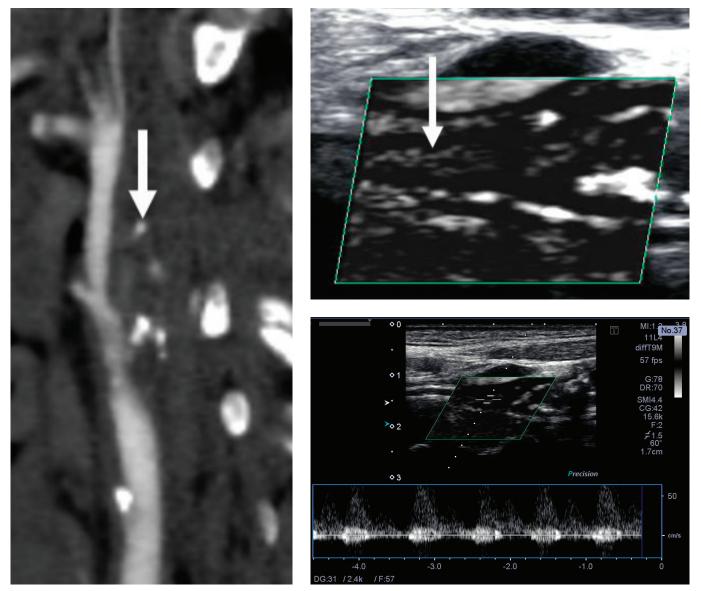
CTA image (left) displaying an occluded internal carotid artery (arrow) and mSMI image (top, right) detecting flow within the same vessel (arrow) and confirmed with cSMI and spectral Doppler (bottom, right).
